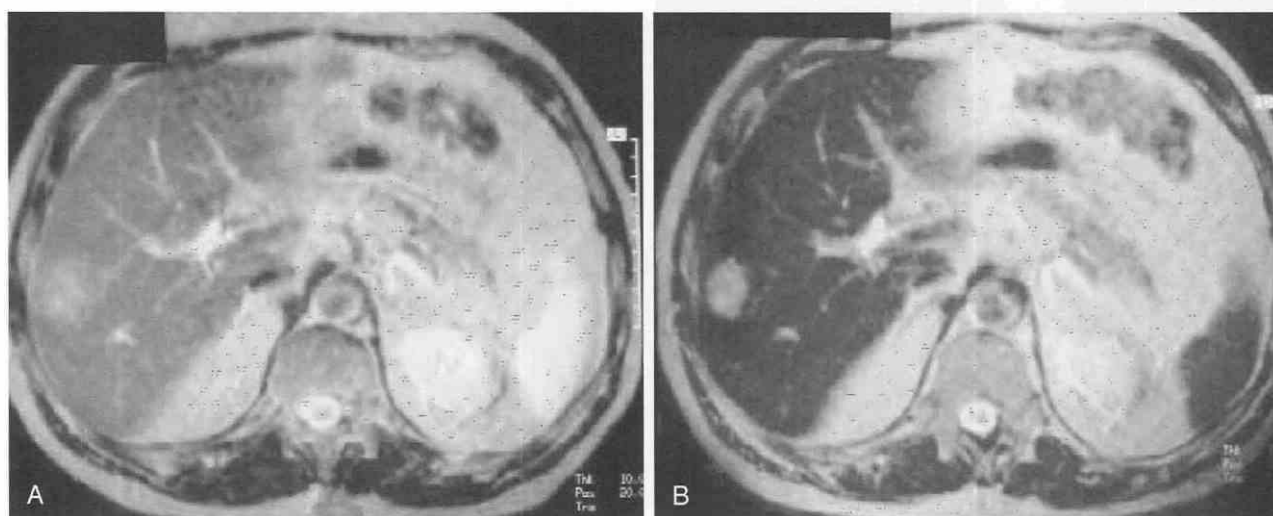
Liver metastases. *A*, Unenhanced T2-weighted image demonstrates a solitary lesion in the right hepatic lobe. *B*, T2-weighted image after administration of superparamagnetic iron oxide (SPIO) shows a second lesion, anterior to the portal vein, not seen on the unenhanced images.
